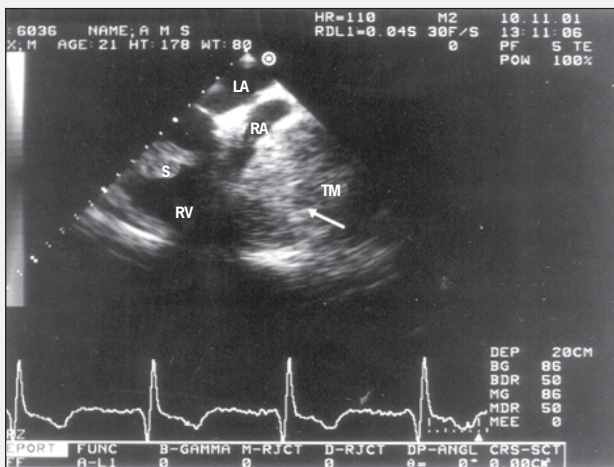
Transesophageal echocardiogram showing a tumor mass compressing the anterolateral and inferior region of the right atrium, reducing the cavity diameter. LA= left atrium, RA= right atrium, RV= right ventricle, S= interventricular septum, TM= tumor mass.
